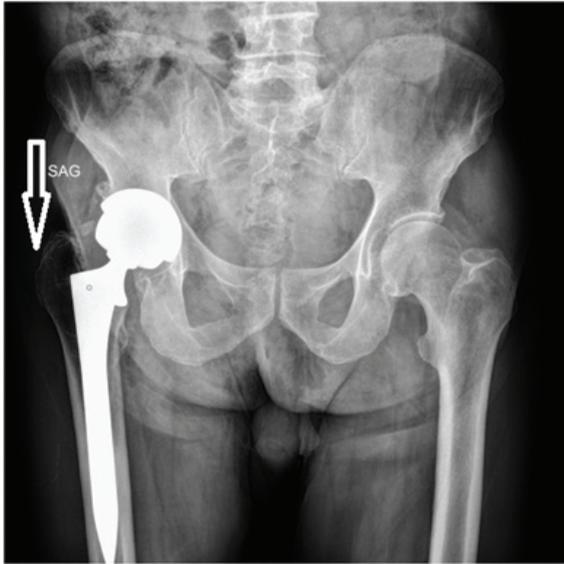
and 4 Stress shielding on x-ray radiographs (white arrow).
